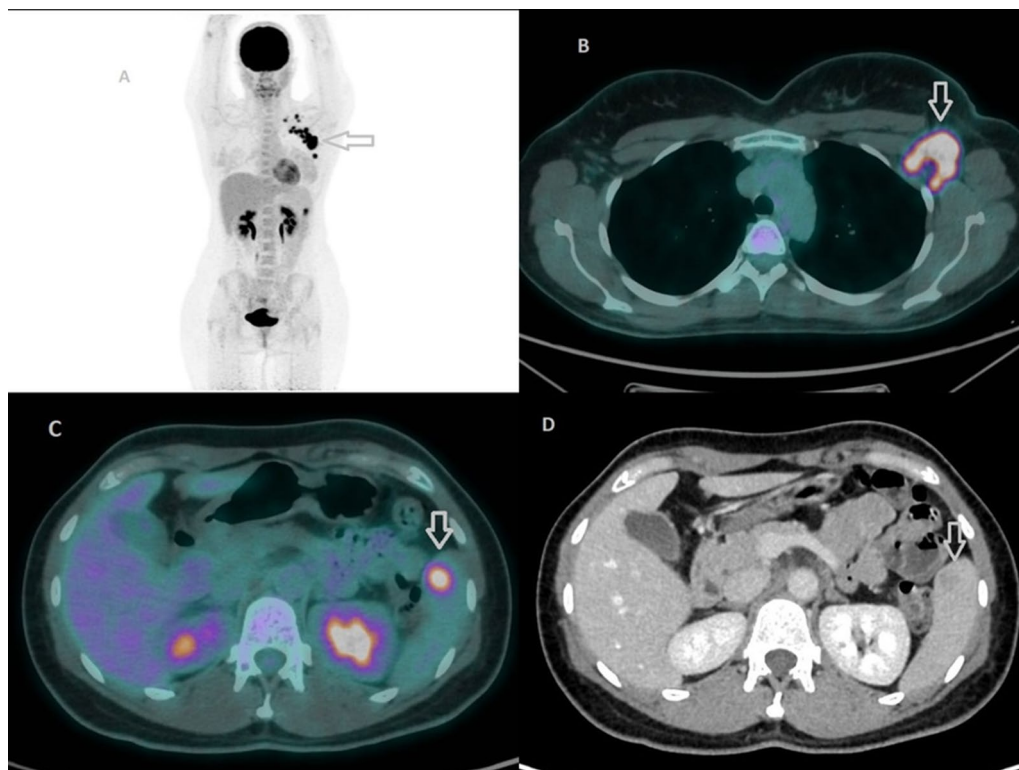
A Maximum intensity projection (MIP) and B fused PET/CT axials from the [¹⁸F]FDG PET/CT scan demonstrate intense radiotracer uptake in multiple axillary, supraclavicular, and retropectoral metabolically active lymph nodes (arrow). [¹⁸F]FDG PET/CT axial slices show a hypermetabolic lesion at the anterior pole of the spleen C, corresponding on CT to a 16 mm hypodense nodule, with hypodense core and rim-enhancement D (arrow)
